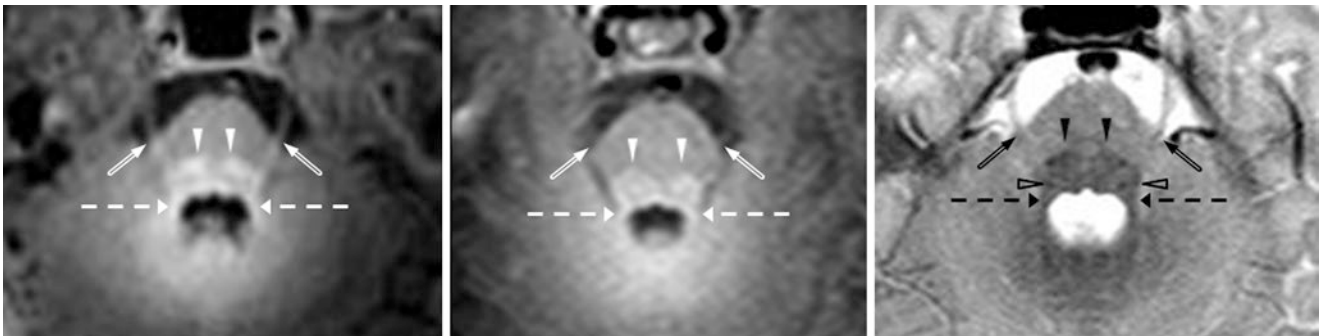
A 4-day-old term neonate had a normal 3T MRI with GE T1WI (*left*), SE T1WI (*middle*), and SE T2WI (*right*). Note the CNV (*beveled arrows*), LL (*open arrowheads*), ML (*arrowheads*), and SCP
